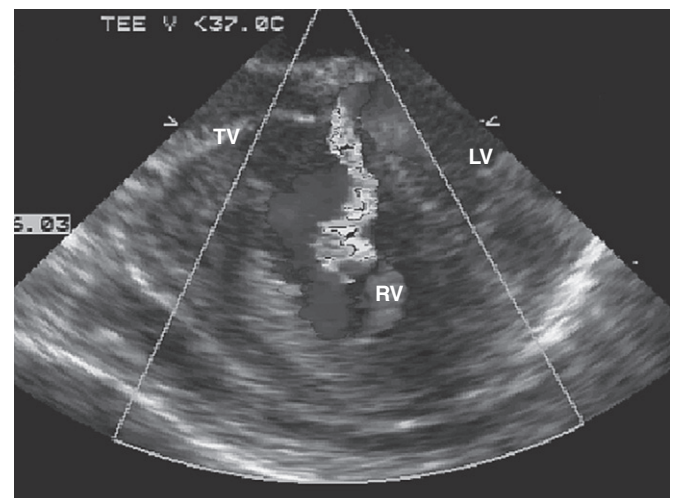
Color Doppler of shunt TEE from the left ventricle (LV) to the right ventricle (RV) through a ventricular septal defect (VSD). The VSD is perimembranous because of its proximity to the tricuspid valve (TV).
